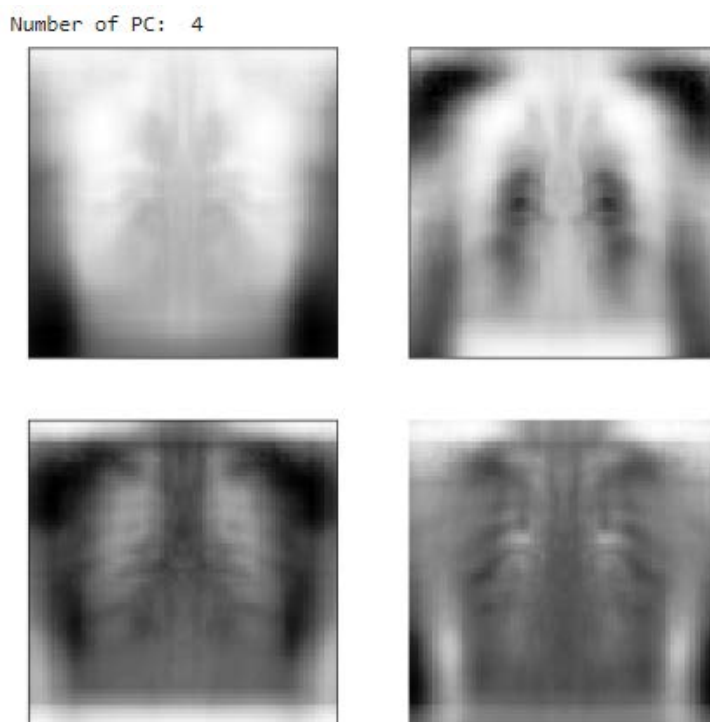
Eigen images of COVID-19 X-ray images.
